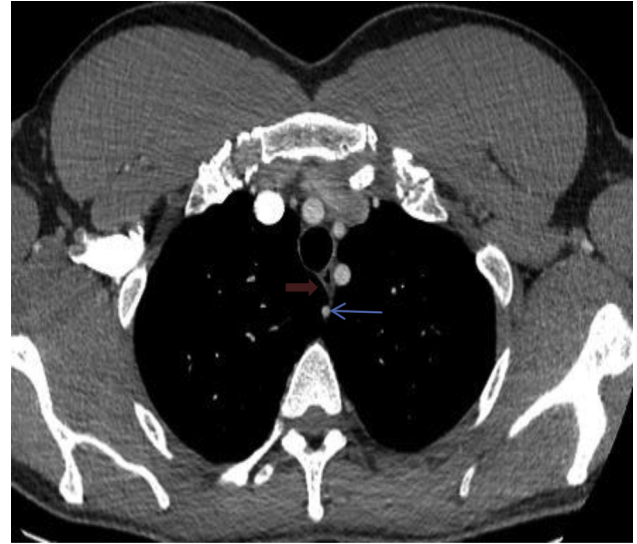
Case 1: Axial image of the CT scan of the chest showing right vertebral artery (blue arrow) crossing the mediastinum posterior to the esophagus (red arrow).
